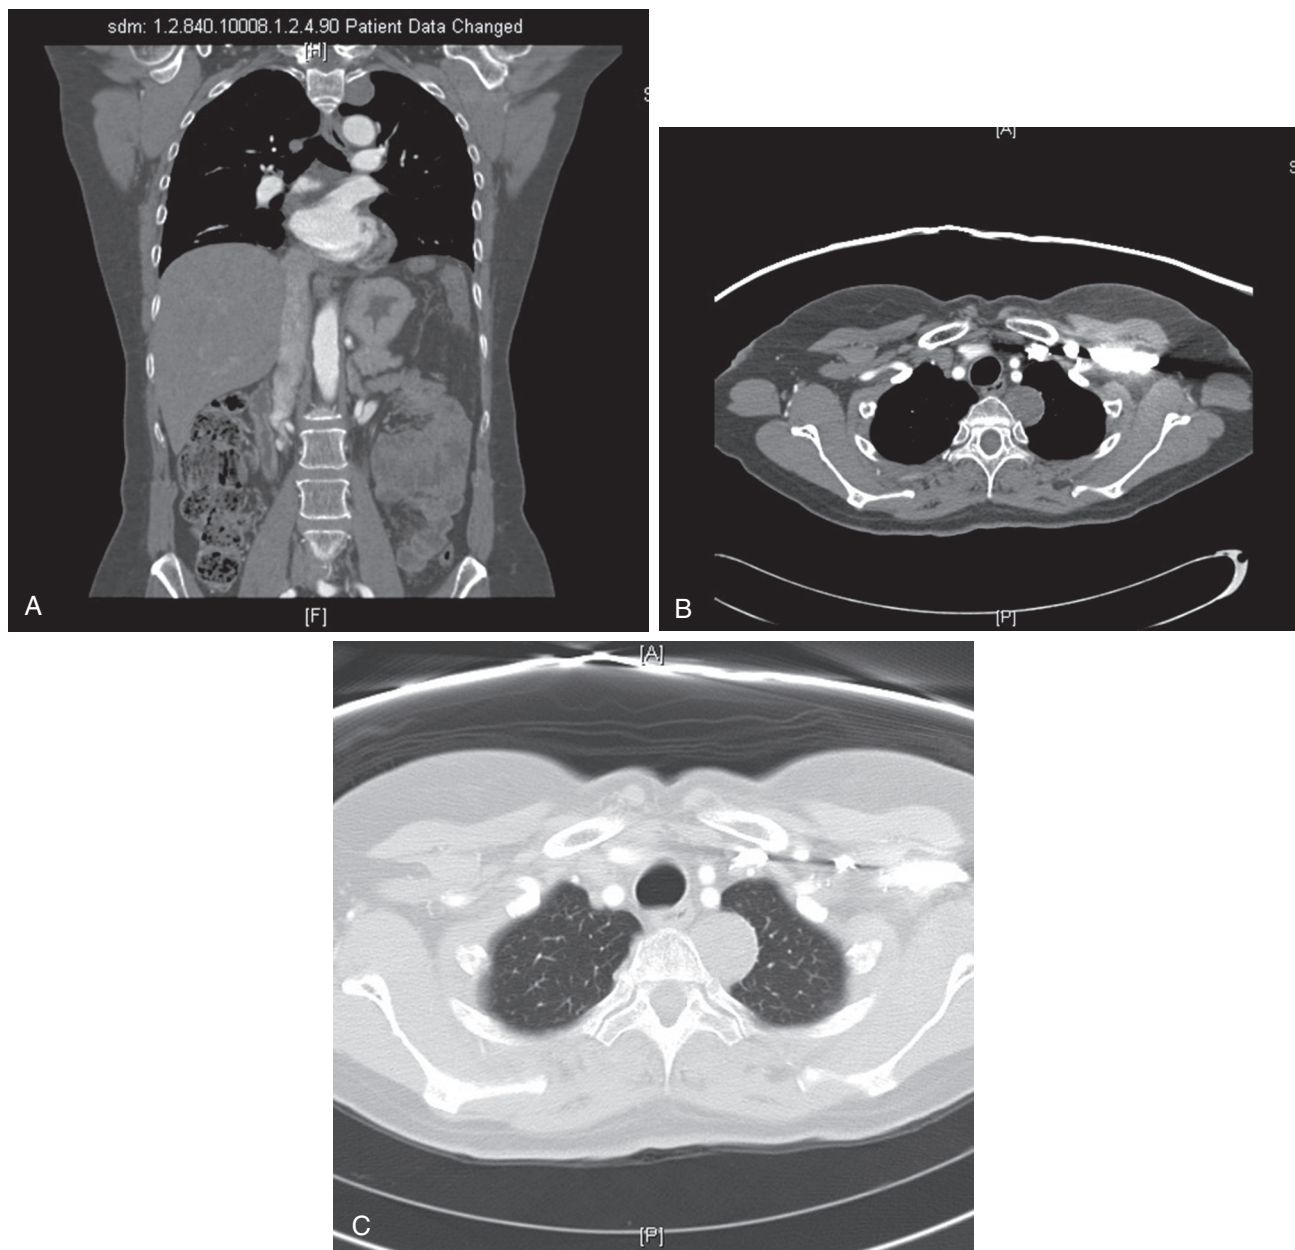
■ A, Schwannoma presenting at the T1-T2 level as seen on (A) coronal CT image. B, Note the proximity to the vertebral body also well seen on the axial image. C, The relationship between the lesion and the lung parenchyma is well demonstrated.
